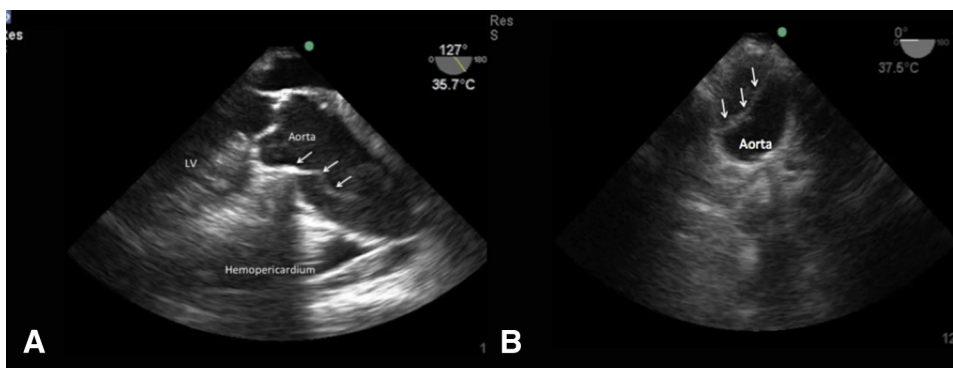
Representative images from 2 separate cases of cardiac arrest determined by transesophageal echocardiography to be due to aortic dissection. (A) Mid-esophageal long-axis view and (B) short-axis view of the descending thoracic aorta. Arrows: dissection flap; LV = left ventricle.
